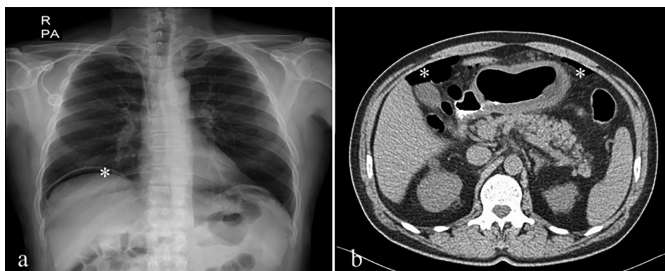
Asterisks indicate free intraperitoneal air in both (a) Posteroanterior chest X-ray and (b) Computed tomography (CT) images.
